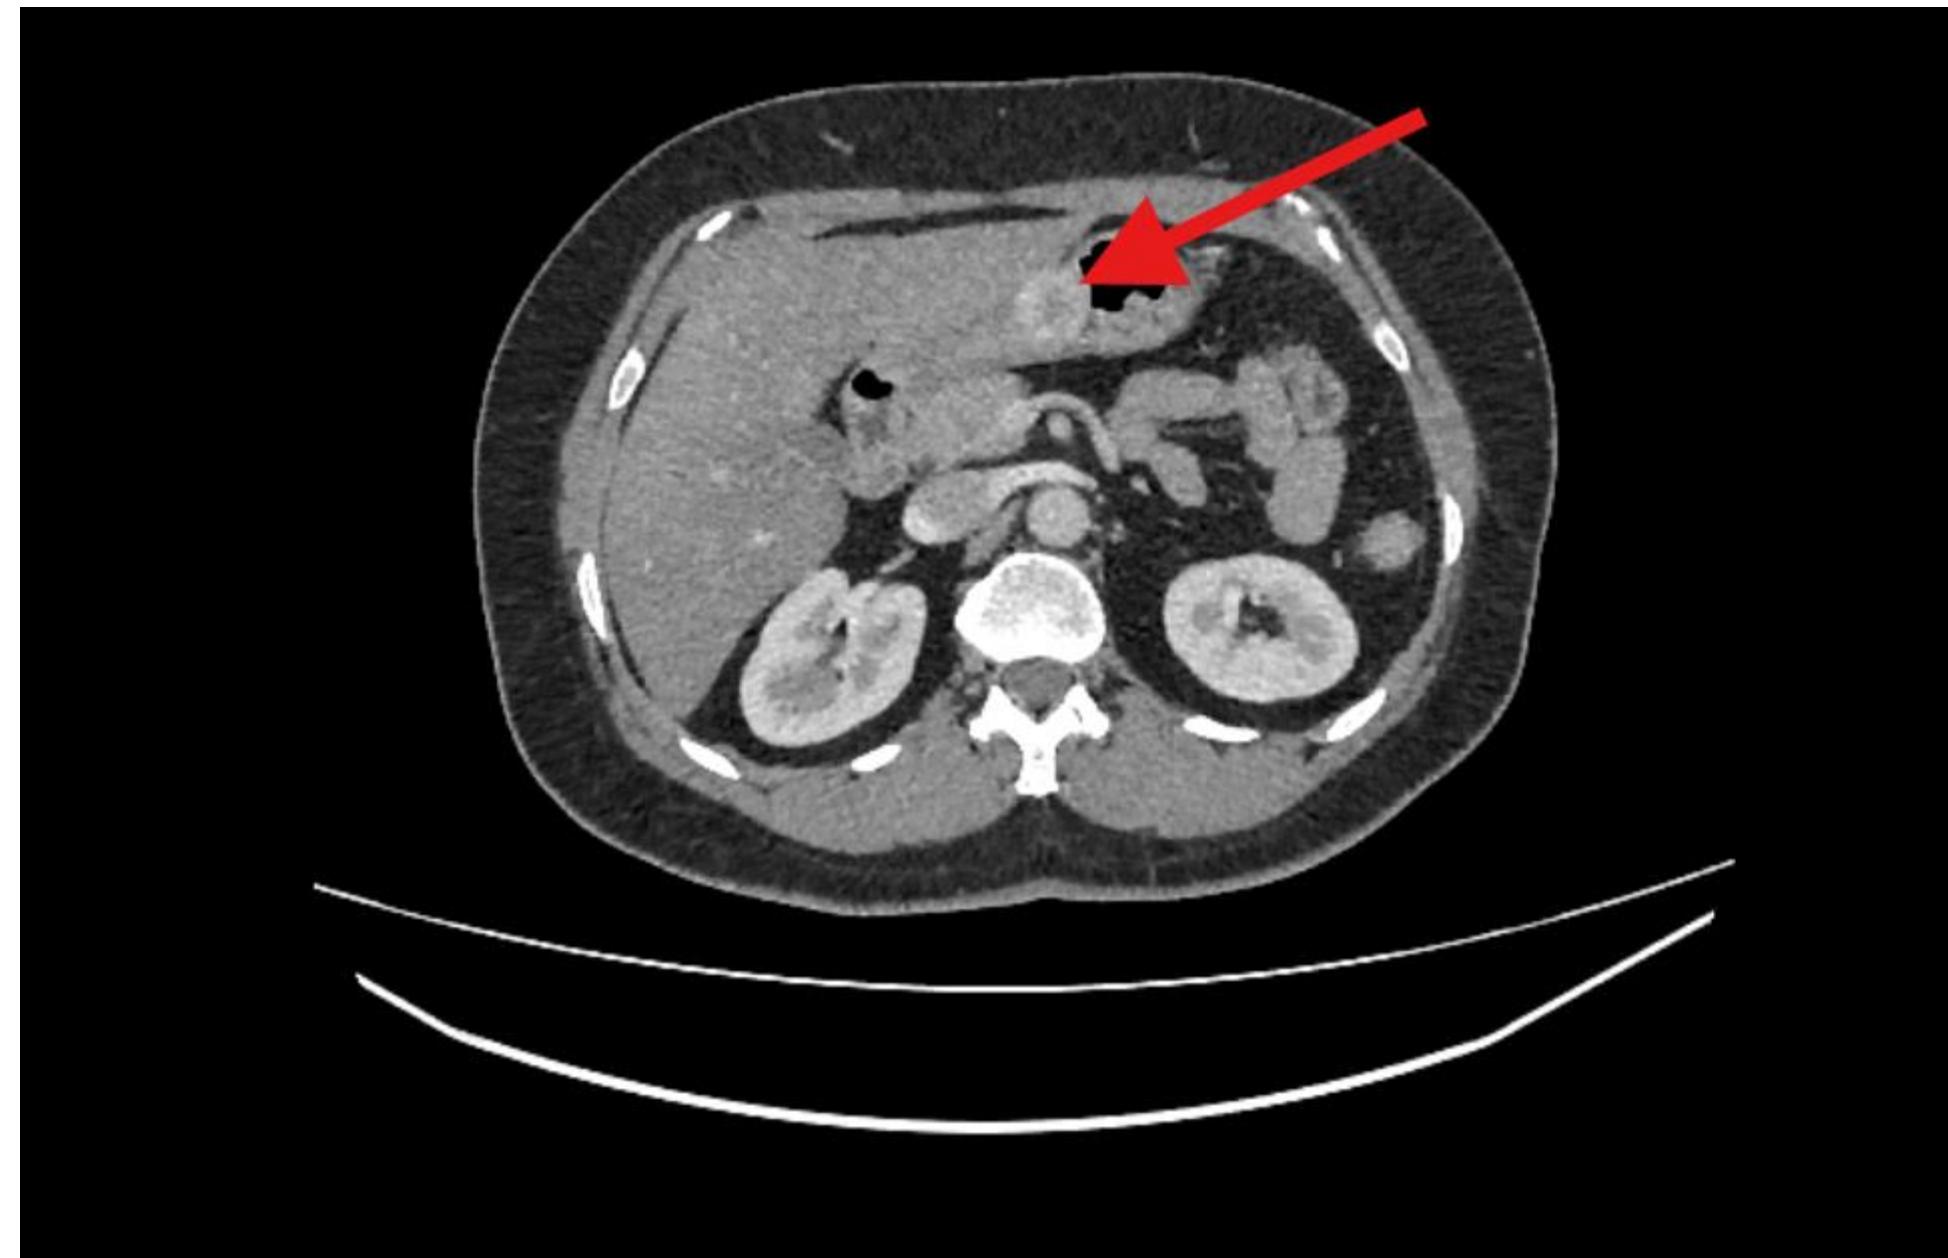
CT Chest and Abdomen showing round circumscribed enhancing mass along the greater curvature of the stomach at the junction of the gastric body and antrum, worrisome for neoplasm.
